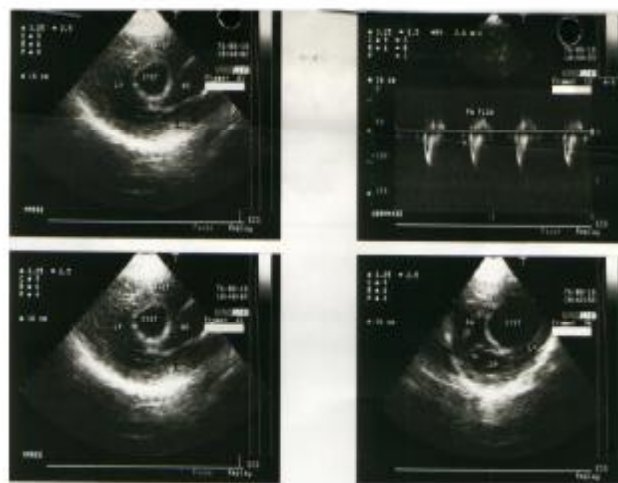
Echocardiography of the first patient showing hydatid cyst in interventricular septum.
